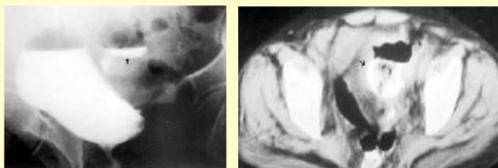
CT scan revealing air in the bladder and a small abscess cavity between the sigmoid colon and the bladder, thus demonstrating fistulous communication between the two.
